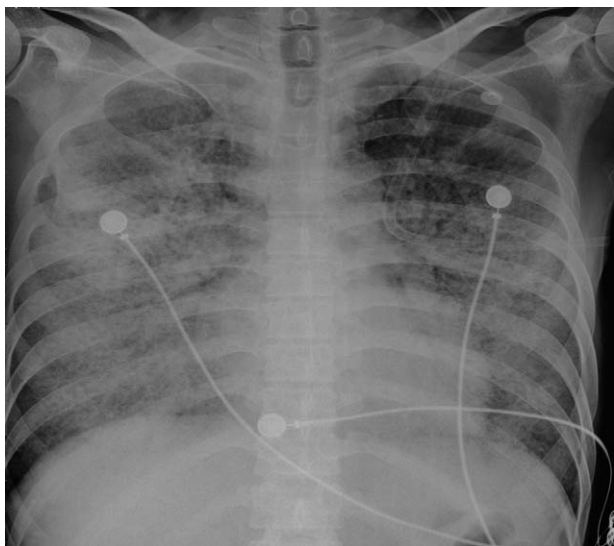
Chest radiograph showing bilateral GGOs. GGO = ground glass opacity.
